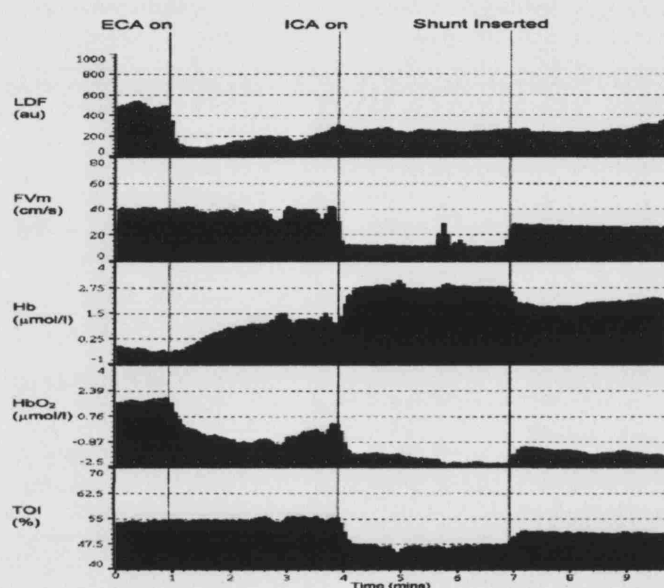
Data obtained from a patient during selective carotid endarterectomy (ECA and ICA external and internal carotid artery respectively; LDF, laser Doppler flow; FVm, flow velocity of middle cerebral artery measured by TCD; Hb, [HHb]). The vertical lines demonstrate time of application of vascular clamps (taken from [18]).
